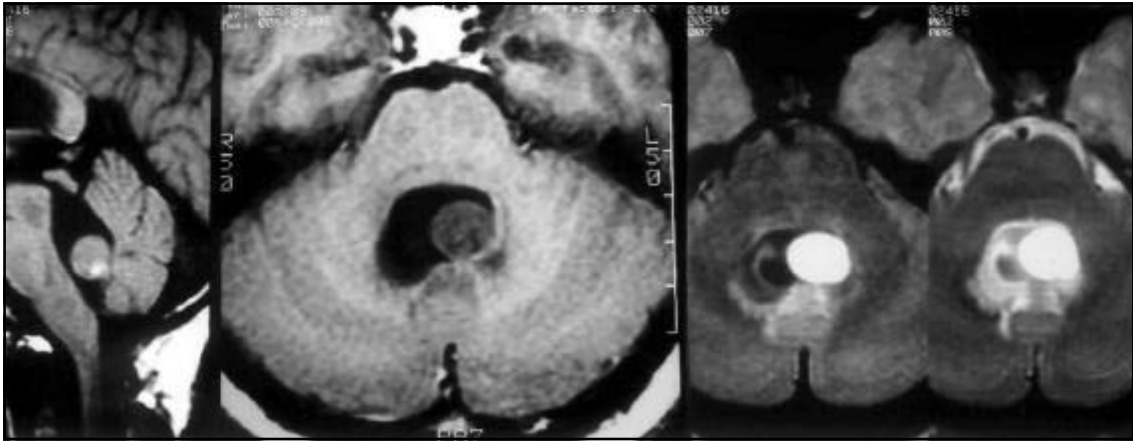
MRI Sagital T1WI, Axial T1WI and Axial T2WI: Cysticercus in the IV ventricle with high protein content.
